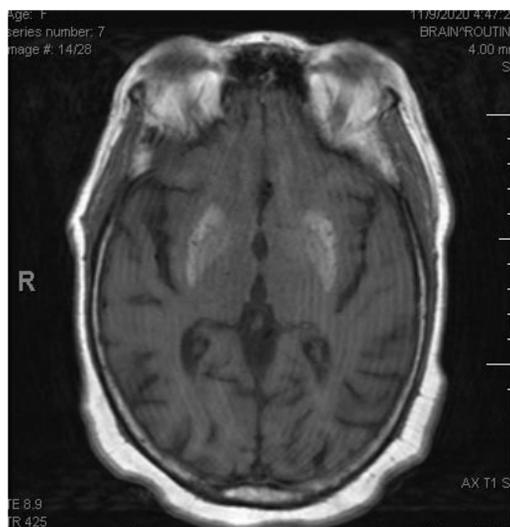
MRI Brain with and without contrast showing prominent bilateral basal ganglia, in particular right caudate, T1 hyper-intensities.
